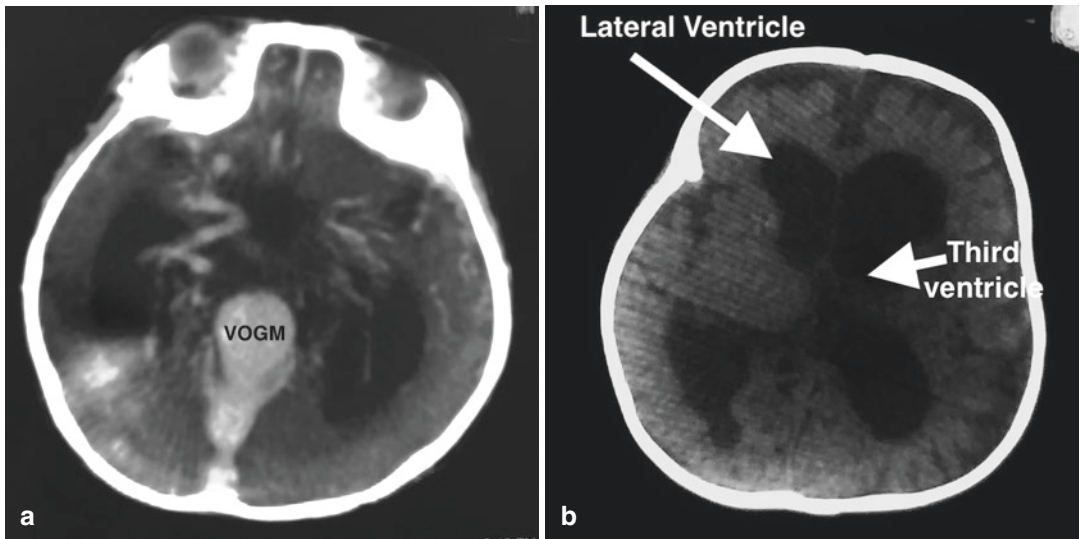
Computed tomography (CT) head axial section. (a) Contrast CT showing midline hyperdense space occupying lesion. (b) Plain CT head showing ventriculomegaly
